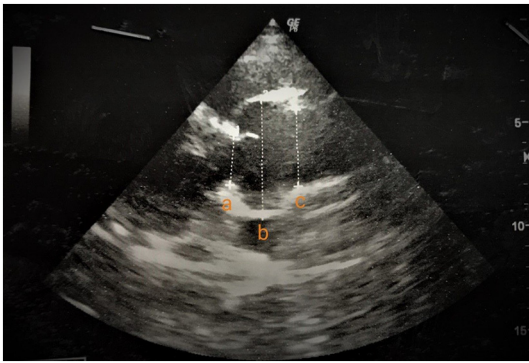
Transthoracic ultrasonography image showing aortic root dilation. The diameter of the aortic annulus was 23 mm (a), the valsalva sinus was 55 mm (b), and sinotubular junction was 36 mm (c).
